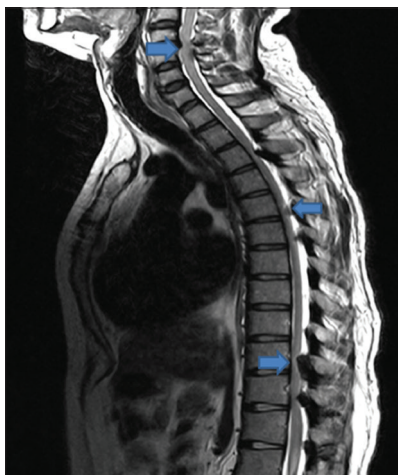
T2-weighted sagittal section showing multilevel ossification of ligamentum flavum (arrows) causing cord compression at multiple levels in cervical and thorax spine
